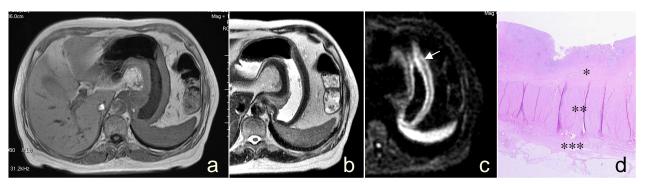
Borrmann-4 gastric cancer. a, FSPGR T1WI displayed uniform signal. b, SSFSE T2WI displayed two-layer signal. c, DWI displayed three-layer signal. d, pathological section showed the three layers on DWI were mucosa/submucosa, muscularis propria, and subserosa/serosa, respectively.
